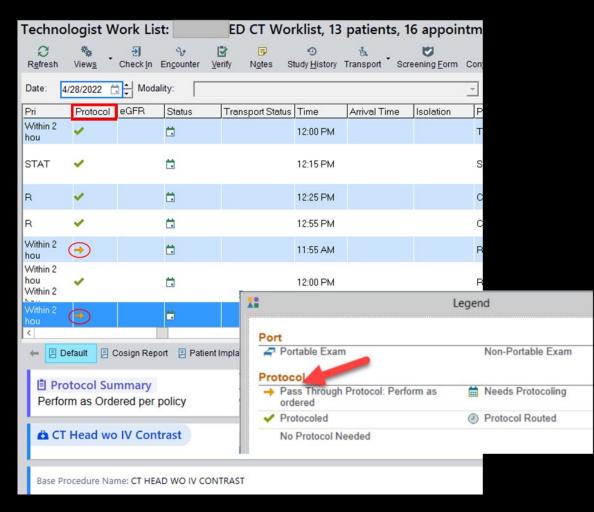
New CT tech worklists.
